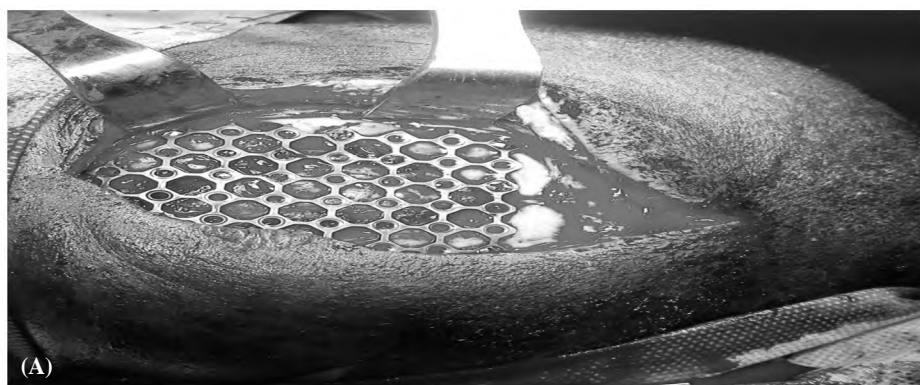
(A) Intraoperative view showing linear incision in right posterior parital region, (B,C) Post-operative CT brain with reconstruction showing the titanium mesh in place.
